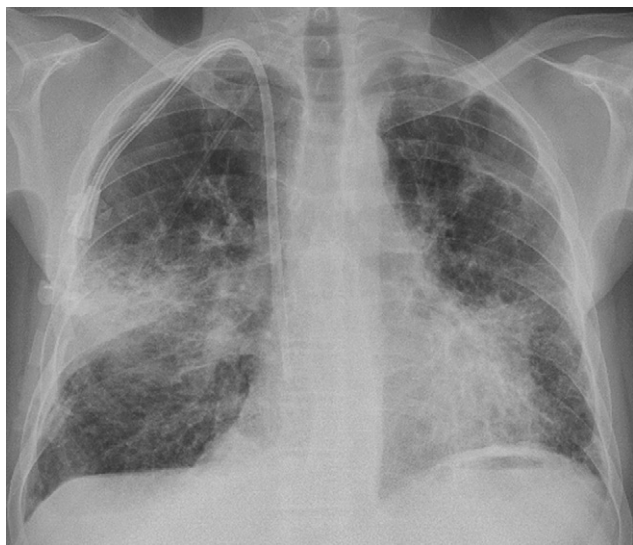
A supine posteroanterior chest radiography demonstrates a consolidation in the base of the right upper lobe. Both lungs show signs of chronic bronchial disease and lung destruction. At the left lung apex there is pleural thickening. A Hickmann catheter is present in the right subclavian vein.
